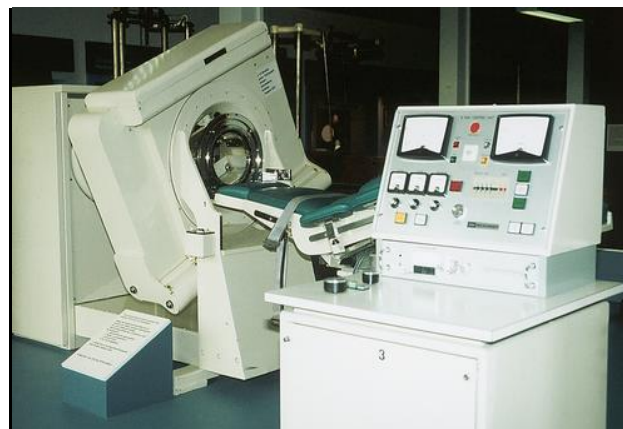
First-generation EMI CT unit: dedicated head scanner. (Courtesy: Wright and Michael, 2020)
